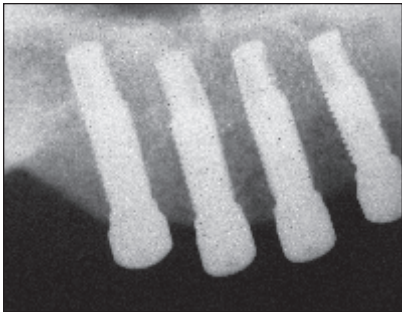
Radiograph of implants at abutment connection.
